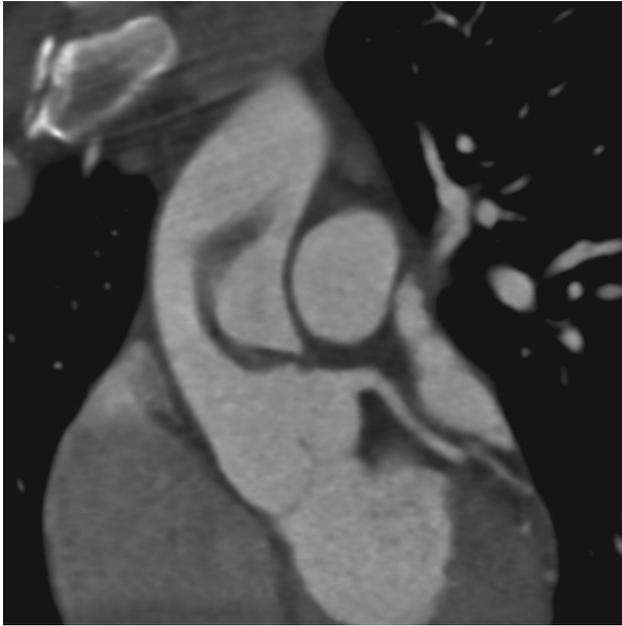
Cardiac and aortic computed tomography demonstrating a 5 cm curvilinear filling defect suggestive of thrombus in the ascending thoracic aorta extending from the sinotubular junction near the left coronary cusp.
